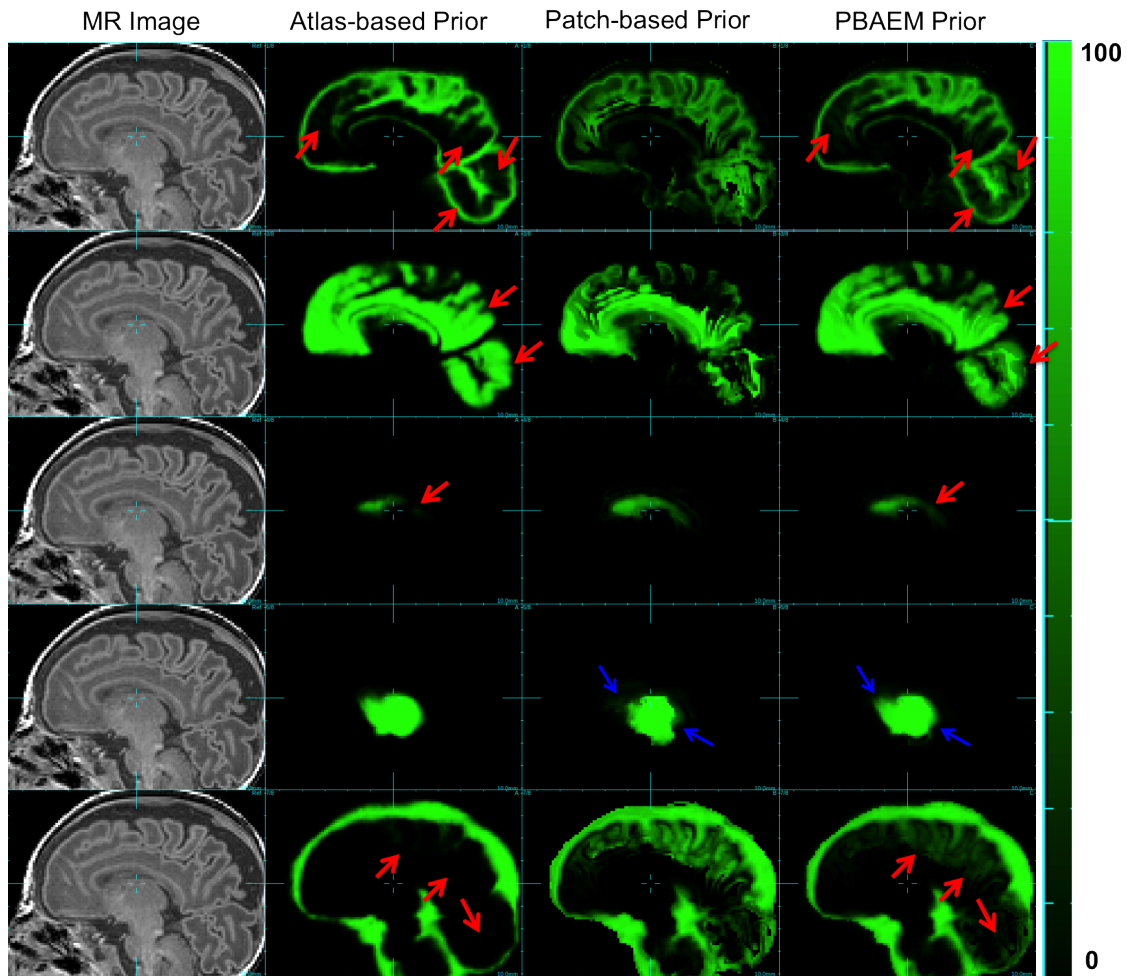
Examples of running priors. From left to right: Raw MR image (column 1), atlas-based (SA-TPM) (column 2), patch-based (column 3) and PBAEM-WF (column 4) tissue probability map of, from top to bottom, GM, WM, VENT, DGM and sCSF of one subject as an example. Tissue probability on a scale 0 - 100. Red arrows: PBAEM-WF tissue probability is more accurate than the atlas-based one; Blue arrows: PBAEM-WF tissue probability is more accurate than the patch-based one.
